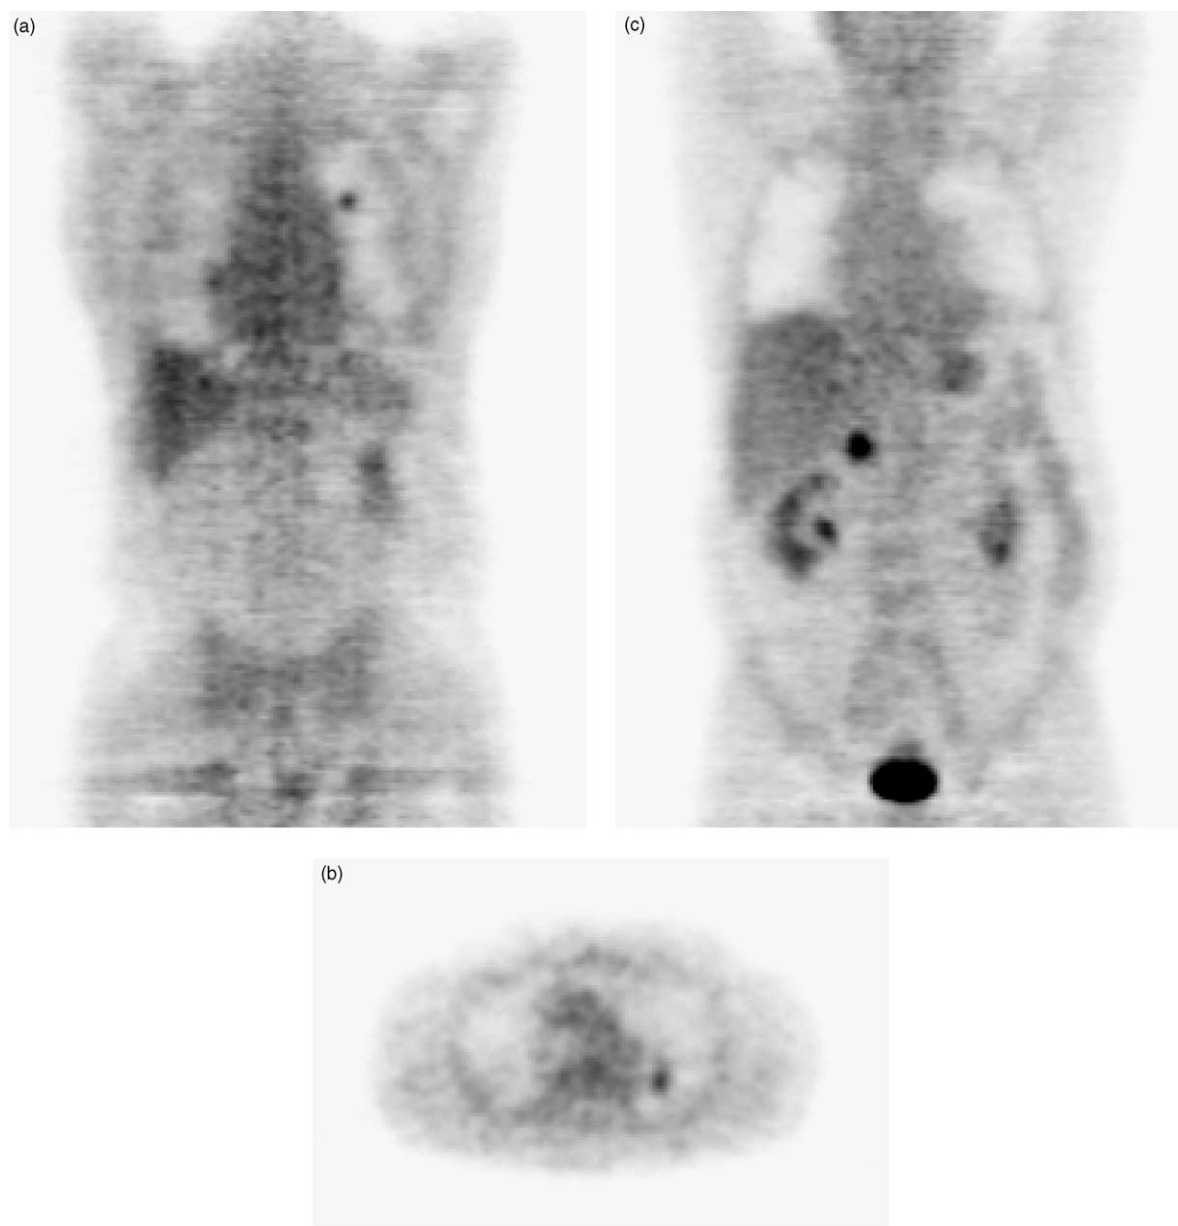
PET scan in a 69-year-old patient with a brain metastasis of unknown origin. FDG-PET shows a lung lesion (a and b) as well as a right adrenal metastasis (c).
